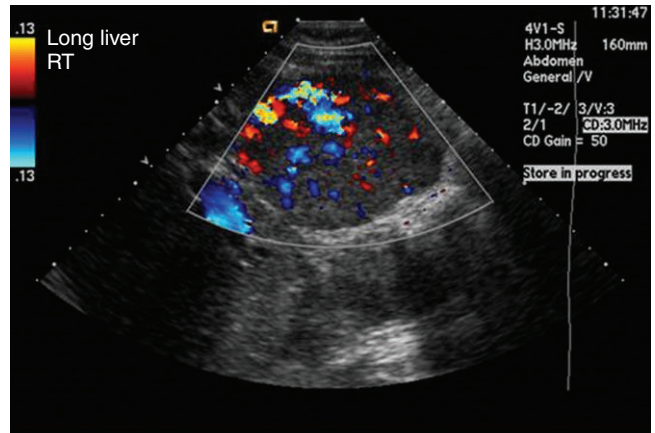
Hypervascular lesion on color Doppler interrogation.
